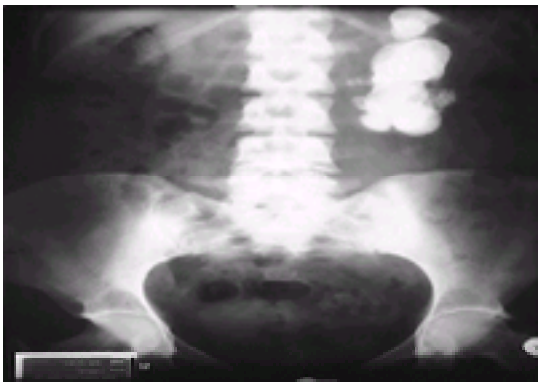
Plain radiograph showing massive nephrolithiasis secondary to hyperparathyroidism.
